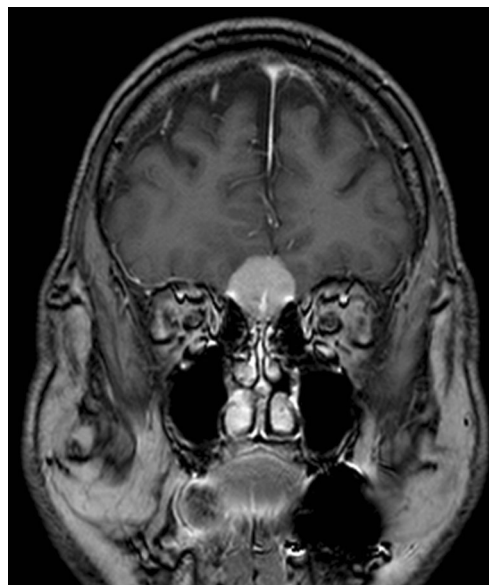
Coronal MRI of a different patient showing bilateral origin/ base of the OGM with extension of the attachment into bilateral ethmoid sinuses
